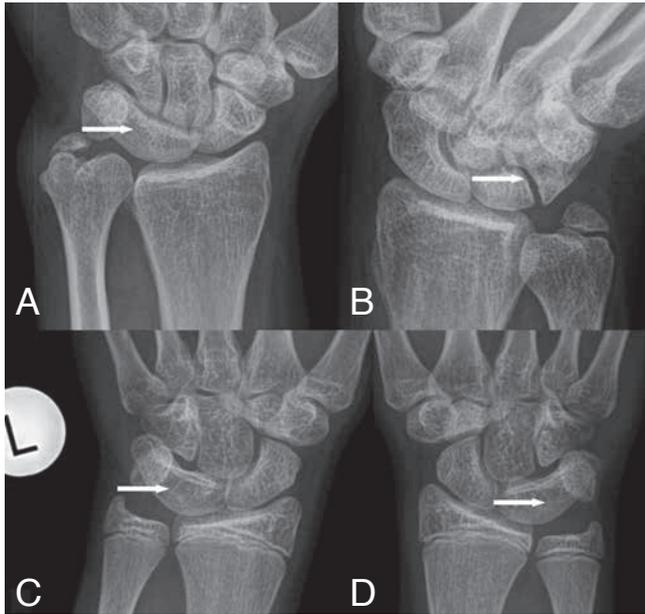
Bilateral LTC in the same patient. Plain radiography. A. Type 3 LTC on the left side and B and type 1 LTC on the right side (patient 2). C and D, LTC type 3 on both sides (patient 6).
